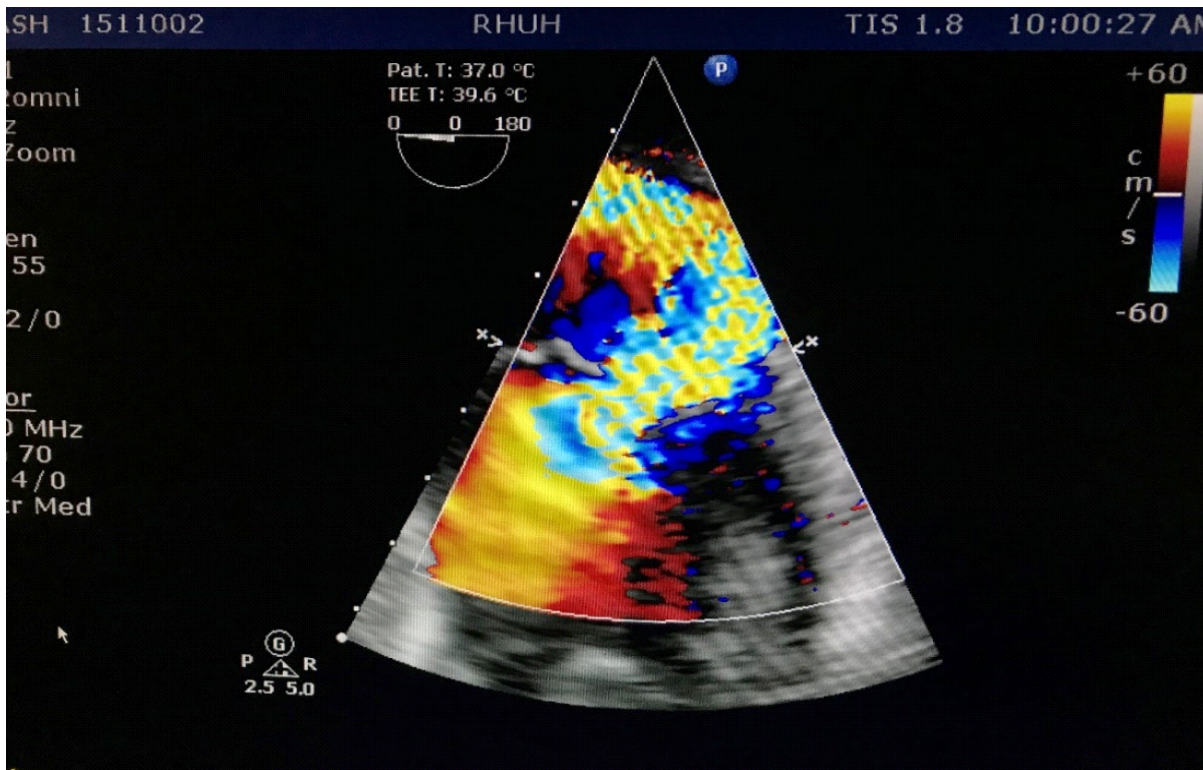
Moderate to severe eccentric mitral regurgitation with color Doppler echocardiography.
